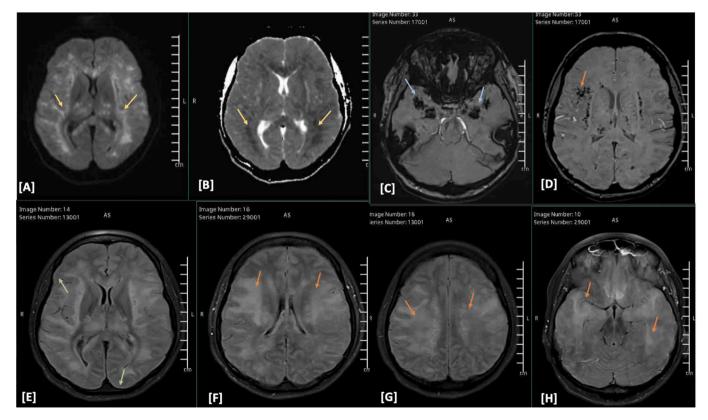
MRI head contrast enhanced.
